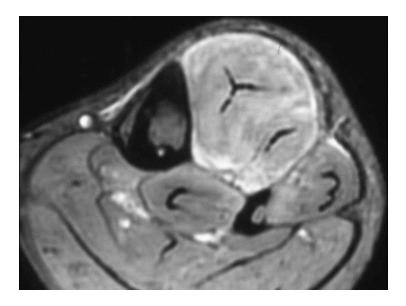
A 32-year-old patient with compartment syndrome of the left leg. Axial fat-suppressed T2-weighted MRI of the left leg after running on a treadmill shows hyperintensity of the muscle in the anterior compartment of the leg
